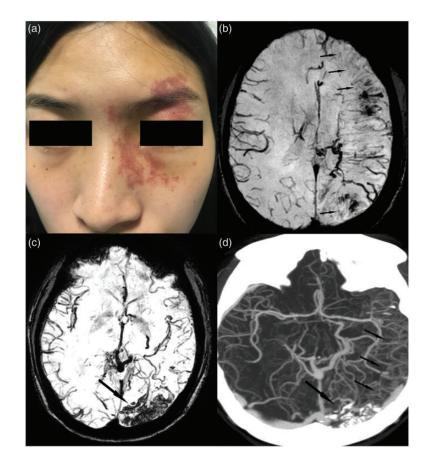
Representative photographs of a 23-year-old pregnant woman with a 20-year history of headache and paroxysmal spasm of the right limb. A port-wine birthmark around the left eye frame (a). Susceptibility weighted magnetic resonance imaging showed the left cerebral hemisphere was atrophied (b, black arrows) and left occipital cortical vascular malformation and calcification (c, black arrow). Computed tomography angiography showed vascular malformation (short arrows) and calcification (long arrow) (d).
